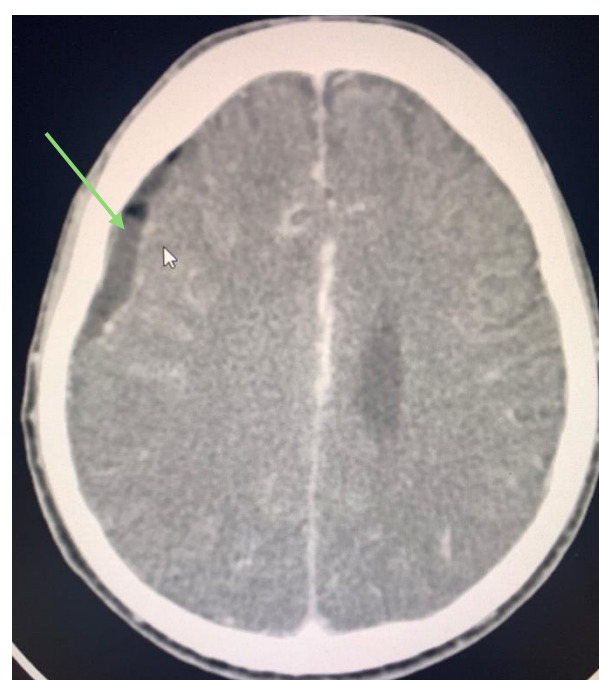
Axial contrast-enhanced CT brain showing a crescentic hypodense lesion along the right frontoparietal convexity (green arrow), suggestive of early subdural abscess or subdural hygroma.
